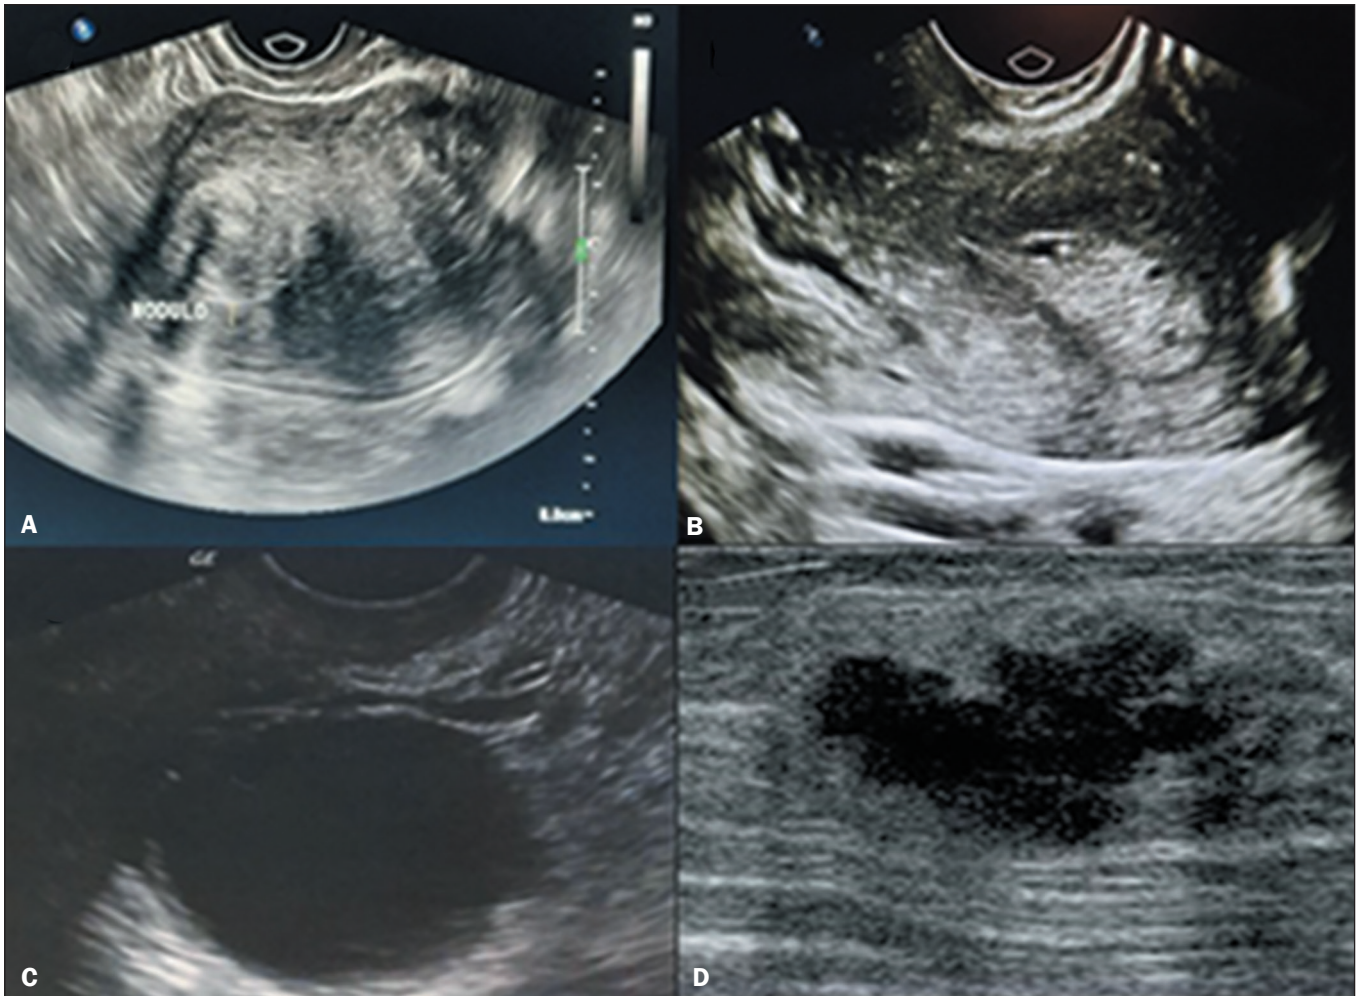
Ultrasonographic findings in female inmates. A: Uterine myoma. B: Uterine polyp. C: Simple ovarian cyst. D: Breast nodule suggestive of malignancy.
